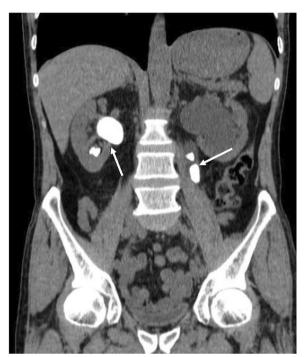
Computed tomography scan of the patient's abdomen. The computed tomography scan of the abdomen reveals a right renal stone and a left ureteral stone (arrows) accompanied by hydronephrosis and enlargement of the kidneys
